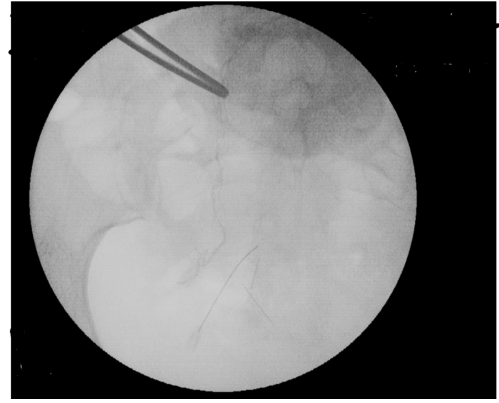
Intra-operative radiograph.
